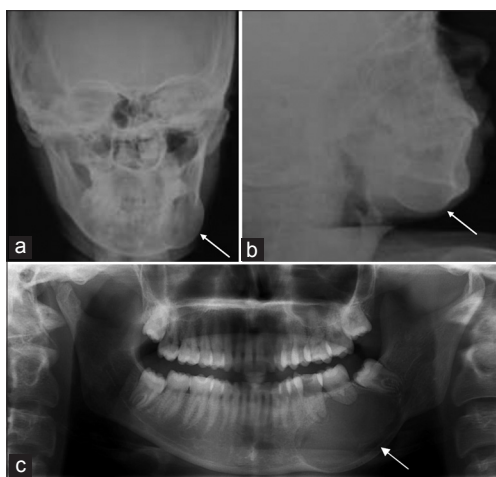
Findings on conventional imaging revealing unilocular osteolytic lesion with cortical expansion and thinning (arrow) in left mandibular body-angle-ramus region. (a) PA view skull, (b) Lateral skull view, (c) orthopantomogram
